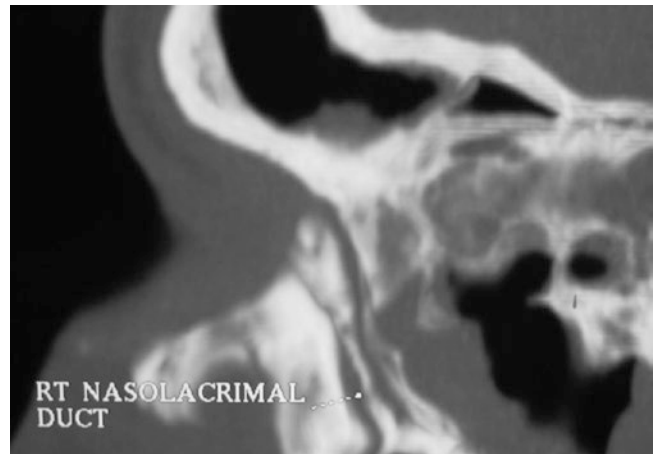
CT-DCG, sagittal reconstruction showing the sac emptying into the nasolacrimal duct
